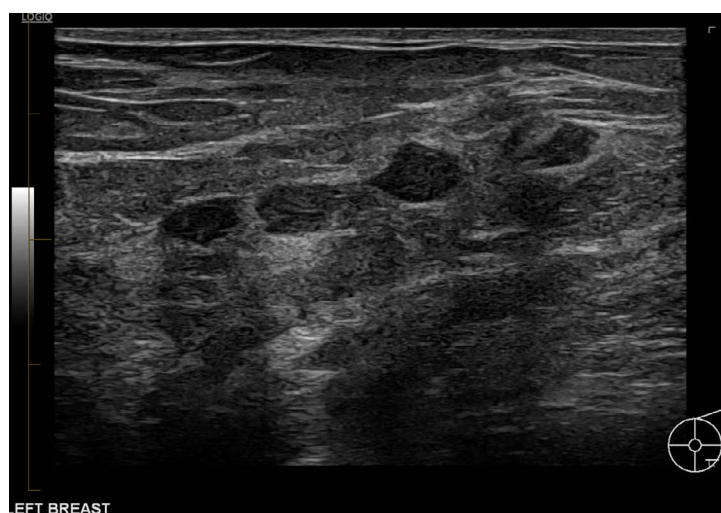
Transverse grayscale ultrasound image of the left breast shows five closely clustered, well-circumscribed, hypoechoic solid masses without internal vascularity, located at the 4 o'clock position, corresponding to the region of concern seen on mammography. The lesions measure up to 11 mm in the transverse plane and demonstrate no associated posterior acoustic enhancement or shadowing.
